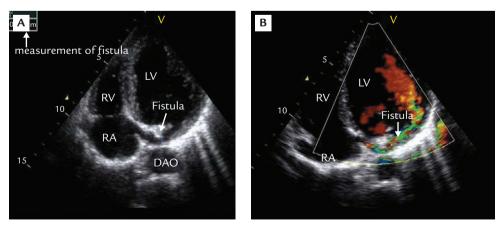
Echocardiography images of atypical long-axis parasternal view show (A) a right coronary artery–left ventricle fistula and (B) aliasing mosaic blood flow (white arrow). DAO = descending aorta; LV = left ventricle; RA = right atrium; RV = right ventricle.
